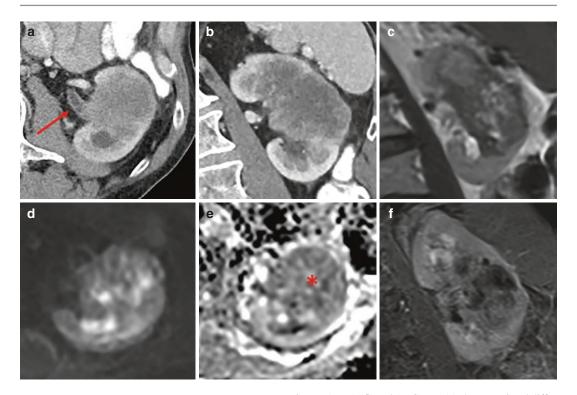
Urothelial carcinoma of the kidney is an infiltrative mass as seen on axial (a) and coronal (b) CT with intravenous contrast and coronal T2 weighted image (c). The mass is typically centered in the renal pelvis as can be seen in this patient (a, red arrow). The kidney preserves its reniform shape unlike central RCC. Diffusion weighted
